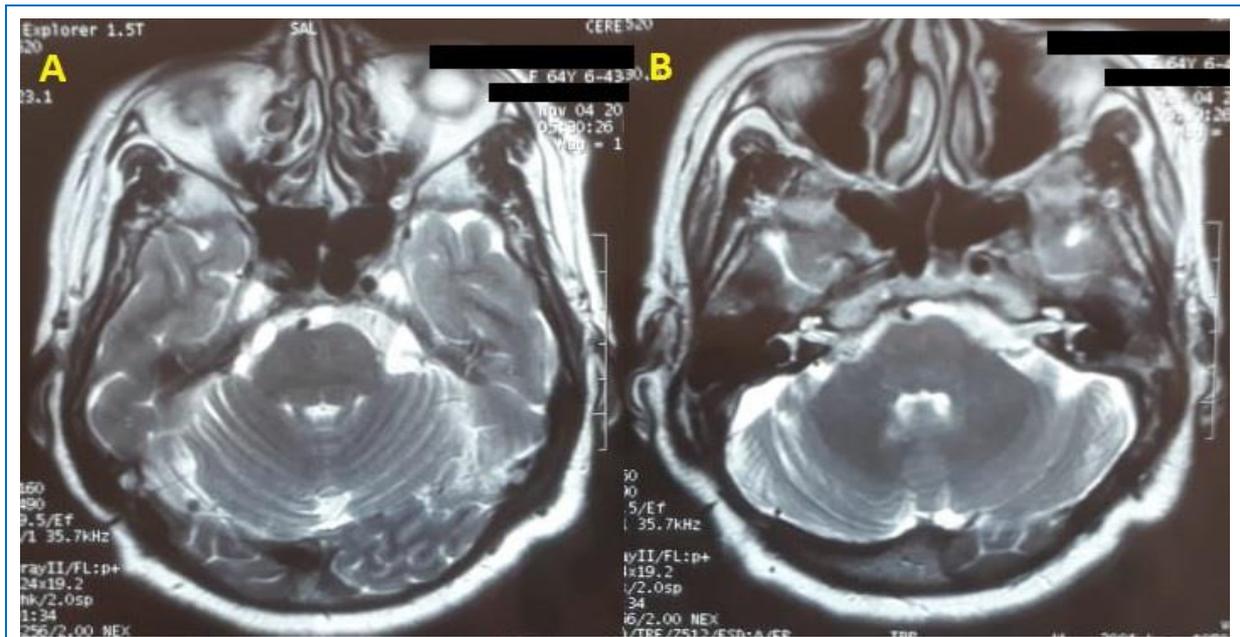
Postoperative brain MRI in T2 sequence showing the absence of tumor in the cerebellopontine angle.
